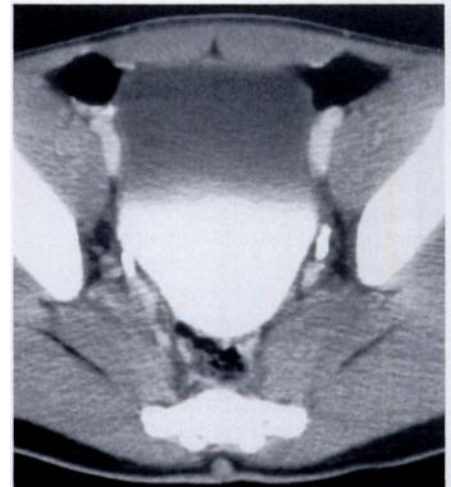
Excretion of iodinated contrast material into the partially filled bladder on CT scan. The transition from pure urine anteriorly into progressively denser contrast material posteriorly is easily understood.
